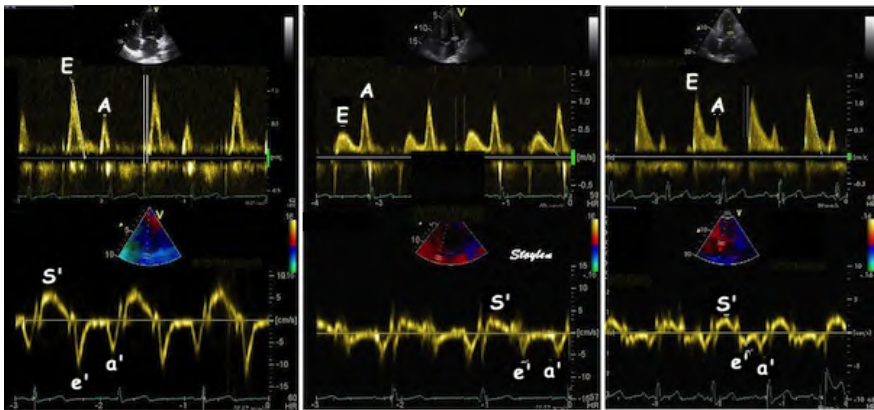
Doppler imaging to assess diastolic function. Top) Pulsed-wave Doppler of mitral inflow. Bottom) Tissue Doppler imaging of the mitral annulus. Left images show a healthy subject with normal diastolic function: high peak mitral flow velocity of the early rapid filling wave (E) and longitudinal motion of the mitral annulus during early diastole (e'), and normal E/e' ratio. Middle echocardiographic images of a subject with diastolic dysfunction without increased filling pressure are displayed. These images presented a low E and e' , and normal E/e' ratio. Right images of a subject with diastolic dysfunction and increased filling pressure evinced high E, low e' and high E/e' ratio. Systolic mitral annulus velocity (S') is also reduced in proportion to e' . The A peak is the late diastolic filling wave due to atrial contraction and the a' peak is the longitudinal motion of the mitral annulus during late diastole. Adapted from https://en.wikipedia.org/wiki/File:Diastolic_function.png#file. By Unknow. This work is licensed under the Creative Commons Attribution-ShareAlike 3.0 License.
